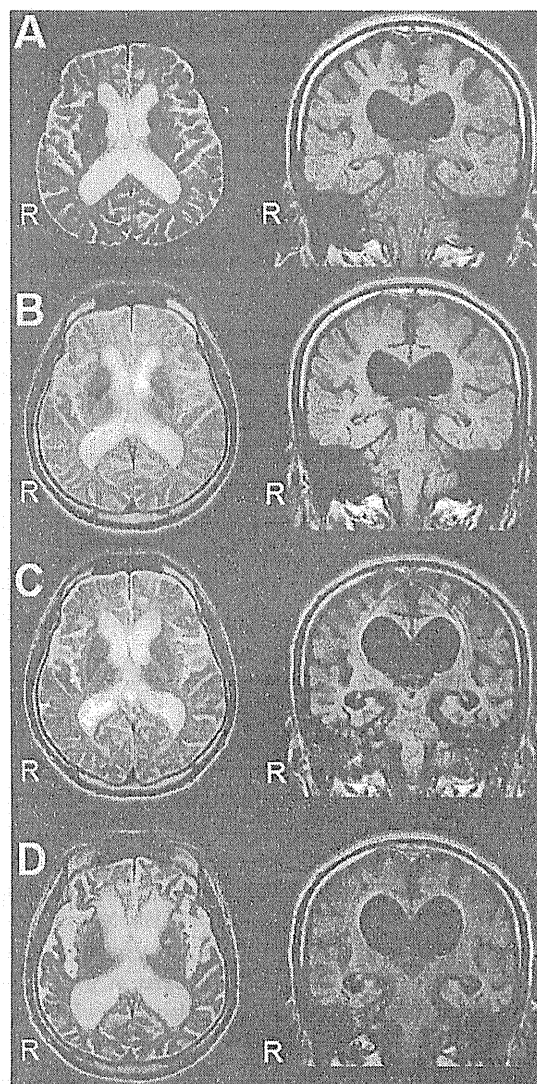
Brain MRI. A, B, C, and D show T2-enhanced images and FLAIR images taken when the patient was 34 and 35 years old, immediately after the onset of convulsive seizures when the patient was 36 years old, and one month after the convulsive seizures, respectively. A comparison of A and B, which represent images taken before the onset of prolonged convulsive seizures, reveals only a mild progression of brain atrophy. In contrast, rapid progression of brain atrophy is evident when comparing C, which represents images taken after the convulsive seizures, and B. D, which represents images taken one month after the convulsive seizures, shows even greater progression of brain atrophy.
